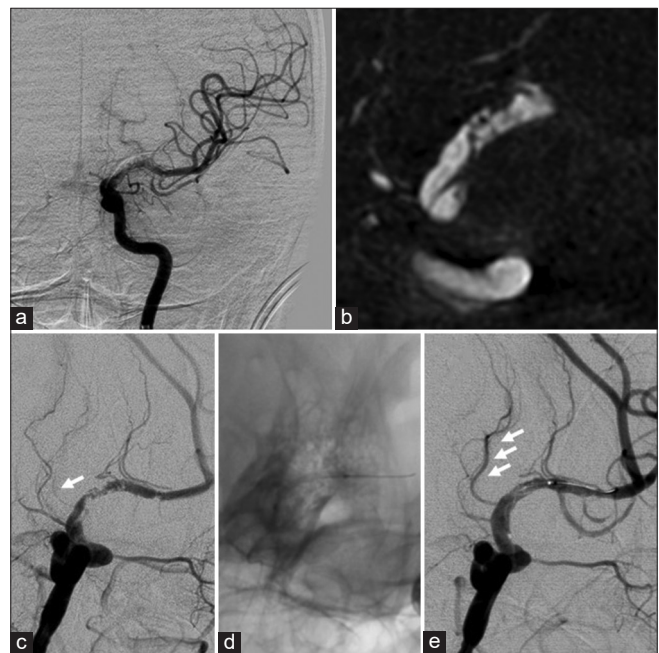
(a) Preoperative angiography revealing irregular stenosis of the left supraclinoid internal carotid artery (ICA). (b) Cone-beam computed tomography demonstrating the intimal flap at the lesion site. (c) Preoperative working angle. Note that the anterior choroidal artery (AChA) is nearly occluded (arrow). (d) Balloon angioplasty performed. (e) Postoperative working angle showing the resolution of the ICA stenosis and the complete recanalization of AChA (arrow).
